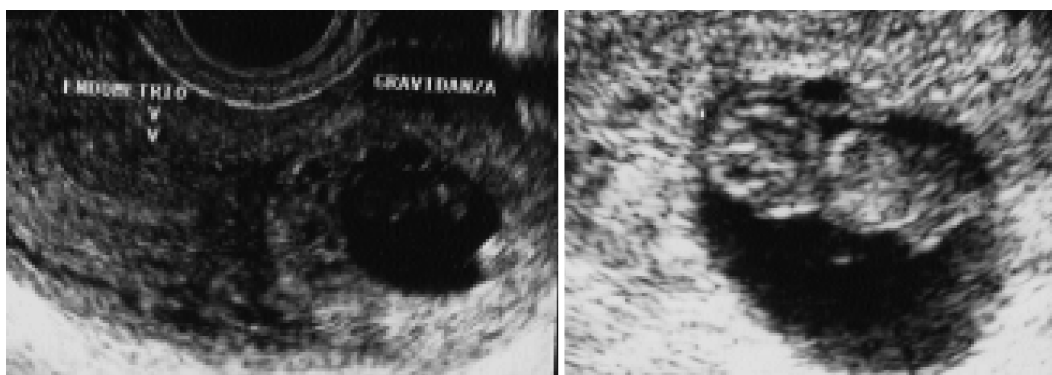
Transvaginal ultrasound scan revealing angular-interstitial pregnancy.
